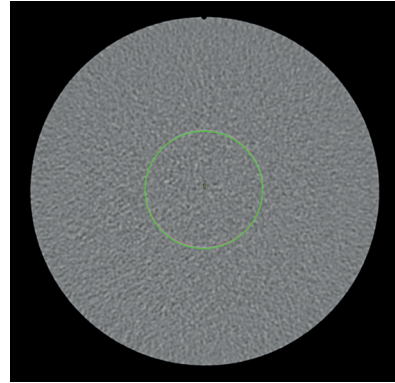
CT Image showing SNR analysis
